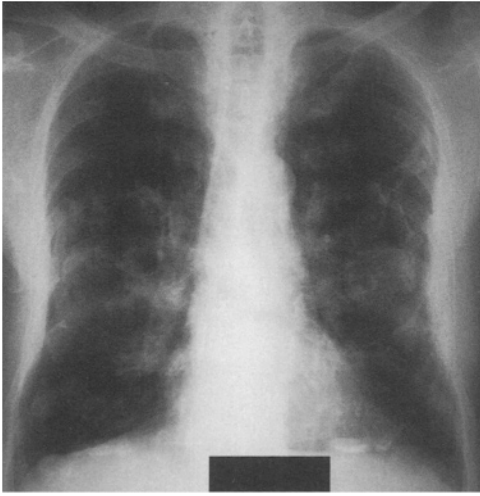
Plain chest radiograph : bilateral calcified pleural plaques are viewed en face and on the diaphragm
